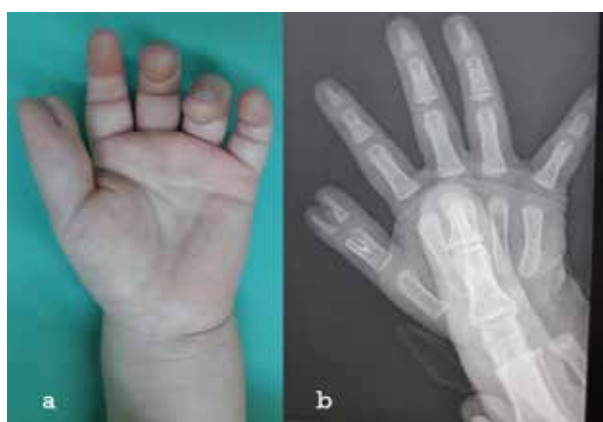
Incomplete thumb duplication of proximal phalanx (τύπος III) a. clinical image b. radiography, in which the mother's index finger is also obvious.
